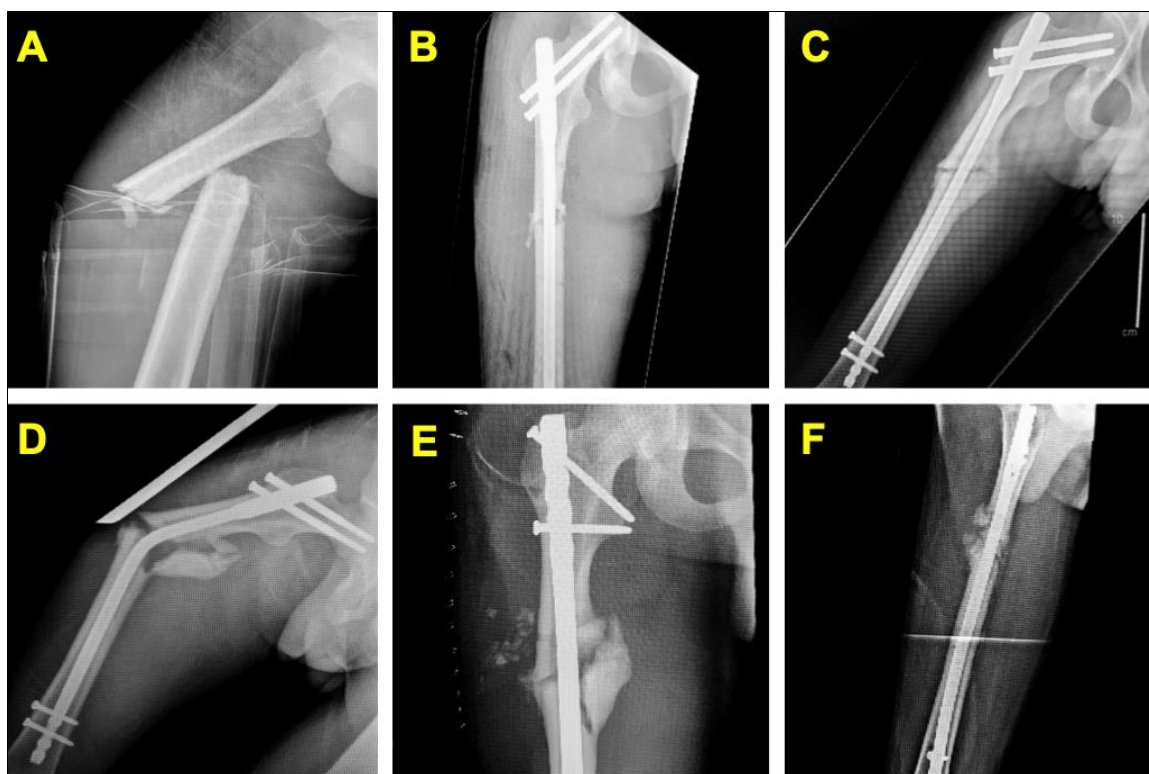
X-Ray images of Right Femur during various stages of treatment in chronological order. A: Initial injury. B: After first operation. C: Post-operative follow-up. D: Subsequent injury. E: After second operation. F: Post-operative follow-up.
